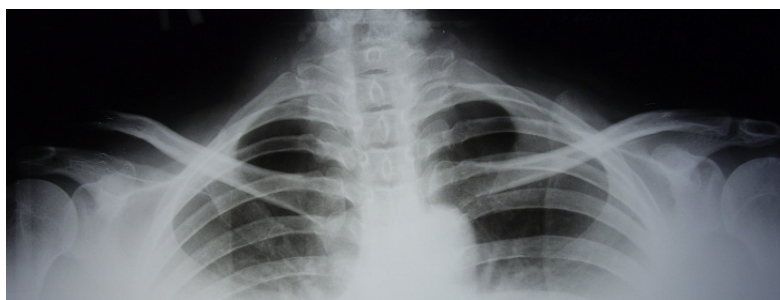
Results of the X-ray examination. The radiogram reveals a dislocation of the acromial end of right clavicle
